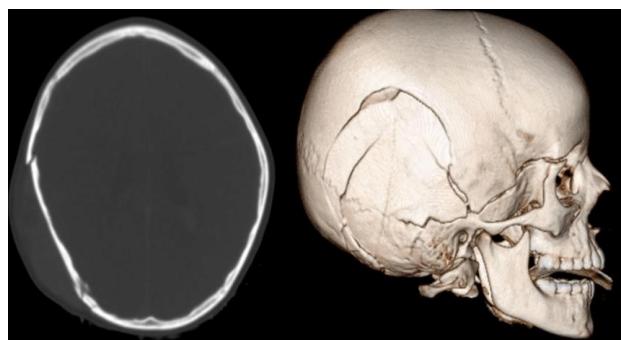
Axial CT head shows a depressed skull fracture of right temporoparietal bone with overlying scalp hematoma, well demonstrated on reconstructed VRT image.
